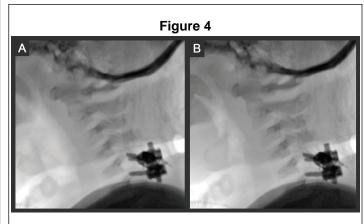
3-Month lateral flexion-extension X-Ray. Postoperative image showing stable fixation and no motion across C5-C6 level.
